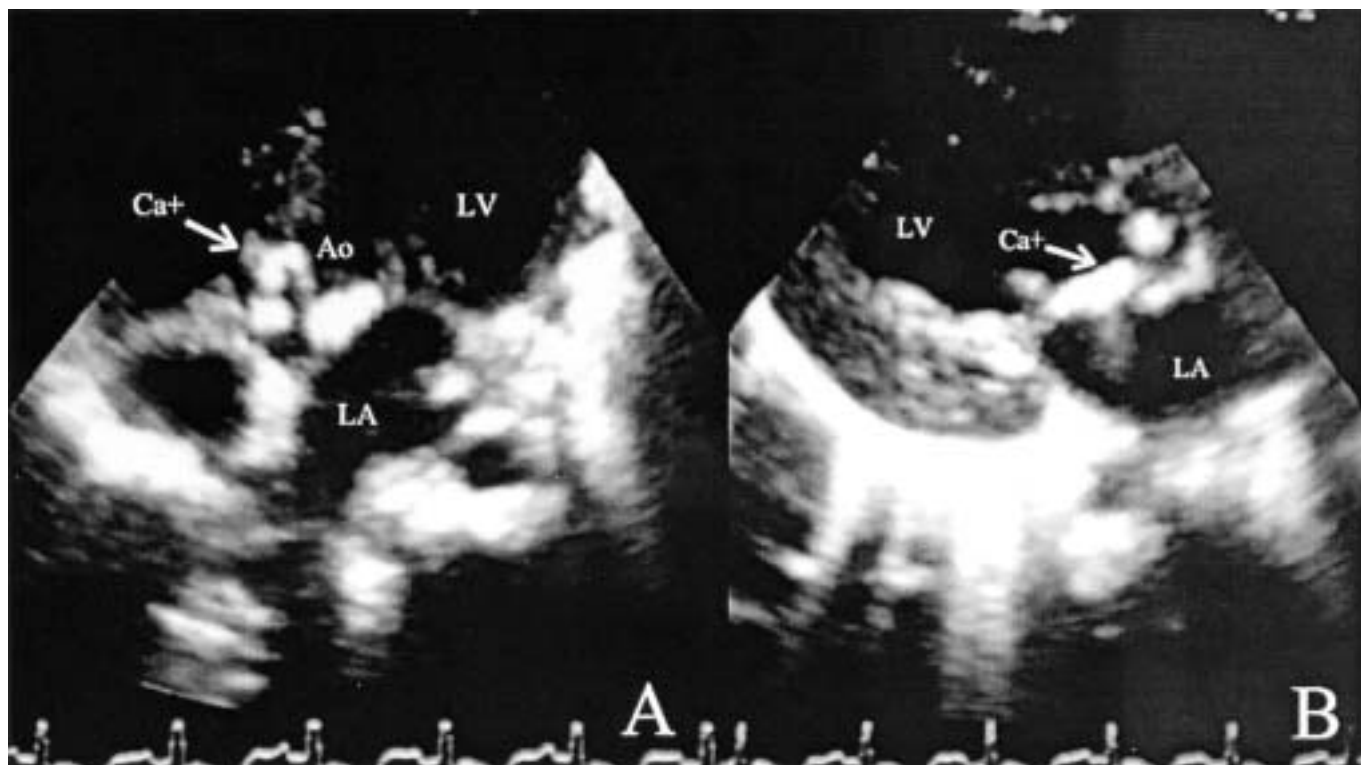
A) Four-chamber echocardiographic view showing calcific deposits (Ca+, arrow) over the aortic valve. B) Parasternal echocardiographic view showing calcium (Ca+, arrow) on the mitral valve. Ao: Aorta; LA: Left atrium; LV: Left ventricle.
